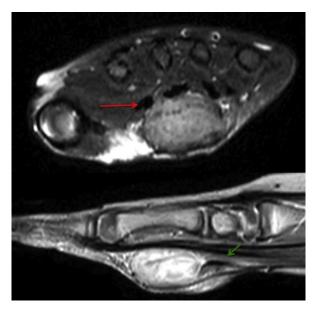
Coronal (top) and sagittal (bottom) views of the magnetic resonance imaging study. The mass was intimately associated with the median nerve and fascicles distally (green arrow). It was superficial to the flexor tendons without direct attachment (red arrow).
